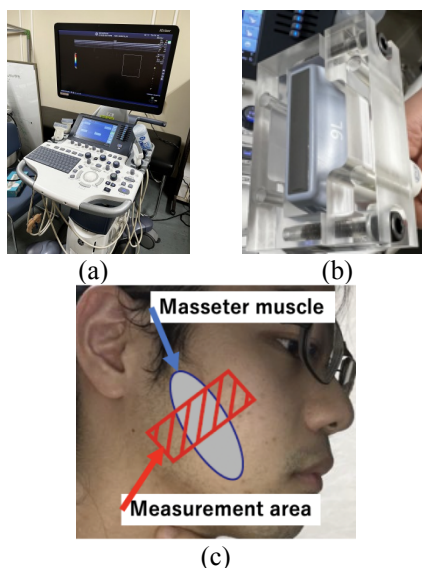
(a) Ultrasonic diagnostic device. (b) Linear array probe with jig. (c) Area of masseter muscle measurement.
